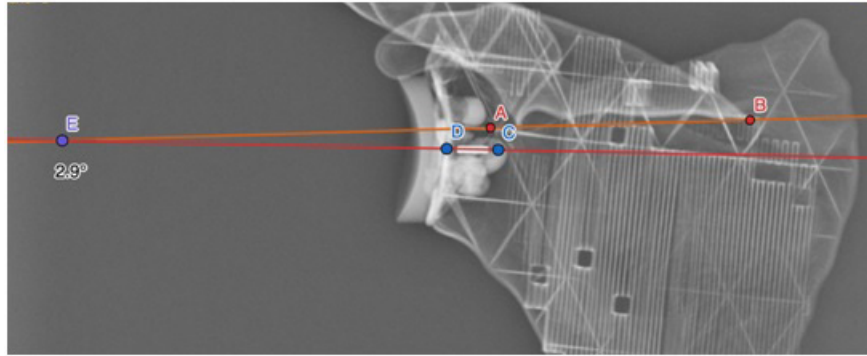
X-ray in anteroposterior view of the model showing the lines and measurement of the angle.
